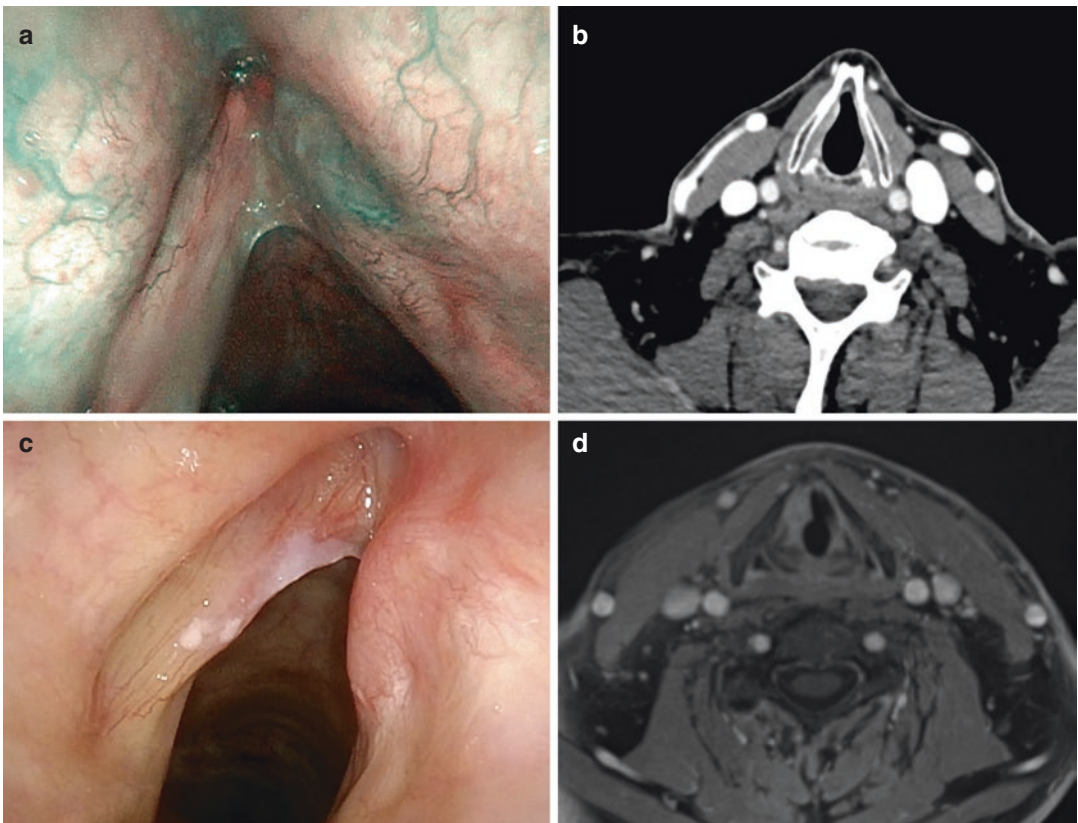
Examples of glottic recurrence: (a–b) superficial recurrence on the right vocal fold in NBI endoscopy and CT, (c–d) submucosal recurrence of the right vocal
